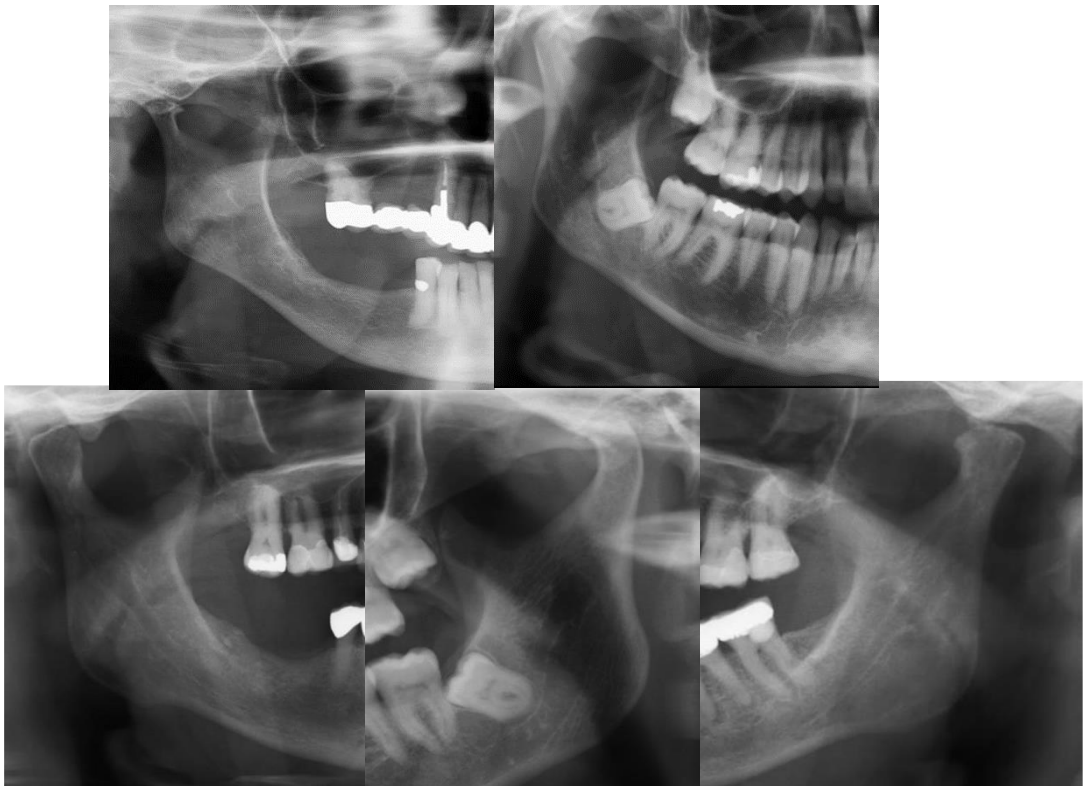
Examples of condylar alterations on panoramic radiographs.
